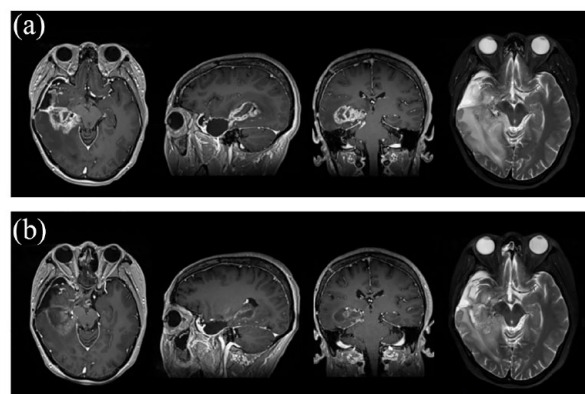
Effect of treatment with anlotinib in one of the patients: (A) MRI image at the time of relapse and (B) MRI image after 1 month of anlotinib treatment. MRI indicates magnetic resonance imaging.
